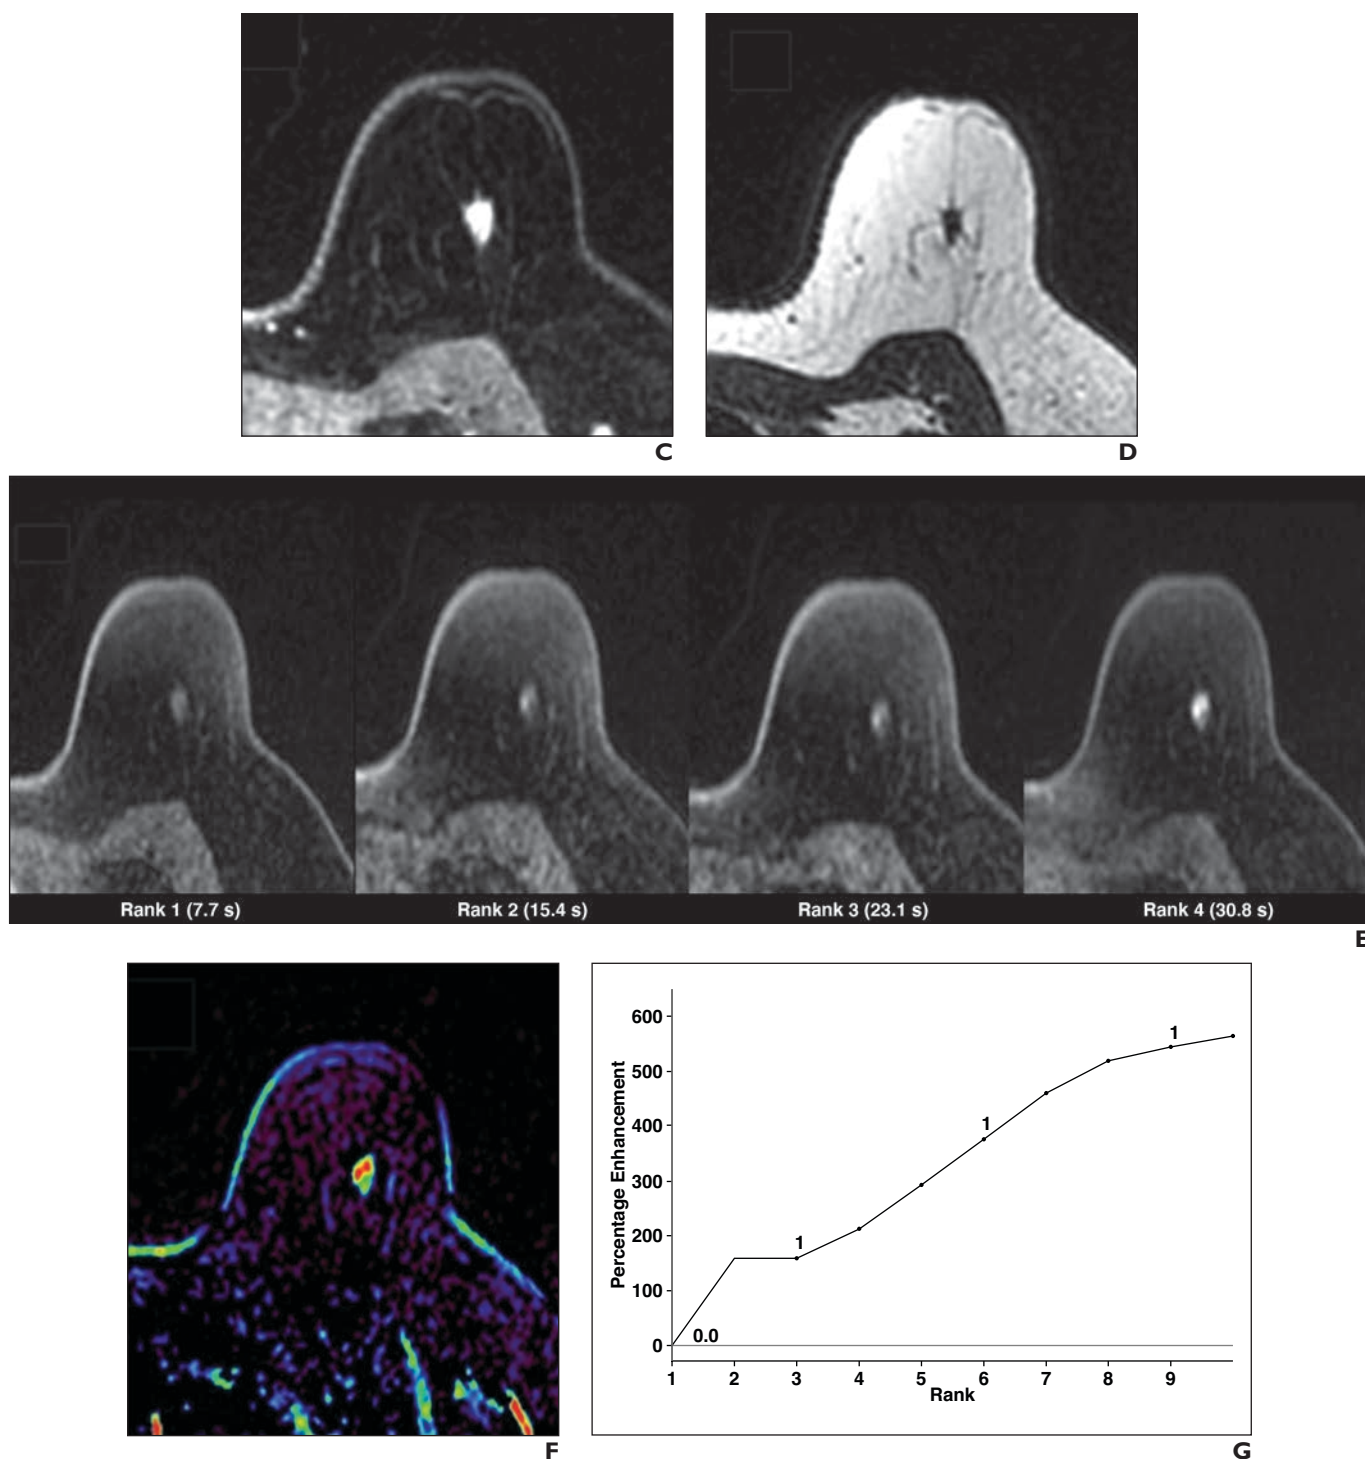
(continued)—45-year-old woman at high risk for breast cancer referred for screening. In this fast protocol including ultrafast sequence, reader needs to classify lesion with T2-weighted sequence, T1-weighted conventional high-spatial-resolution sequence, first T1-weighted fat-saturated conventional sequence after contrast material injection, ultrafast DISCO sequence (GE Healthcare; technique uses view-sharing and undersampling of k-space periphery) with temporal resolution of 7.7 s for each rank. Postprocessing images derived from T1-weighted conventional sequence and ultrafast sequence were also analyzed.
